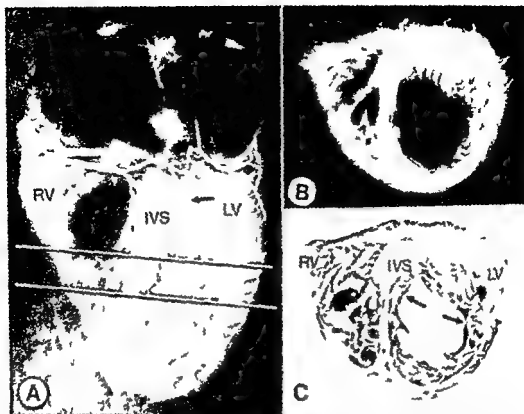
A through C A Postmortem coronary arteriogram The left anterior descending coronary artery is severely narrowed in its proximal portion (arrow) and its distal branches are poorly filled. The apical region of the left ventricle is expanded B Radiograph of transverse section of the heart at the level shown by lines in A The infarcted anterior septal wall is markedly thinned compared to the surviving inferior lateral wall C Cross phot graph of the same heart section shown in B The infarct margins are at the arrows The expansion of the infarct is shown by the lateral displacement of the anterior papillary muscle complex
